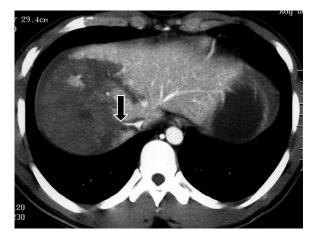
Hepatic venous injury. Contrast-enhanced CT scan shows a laceration that extends into the IVC and cutoff of right hepatic venous drainage (arrow). Hemorrhagic fluid is seen around the IVC. Surgery revealed a laceration of the right hepatic vein.
